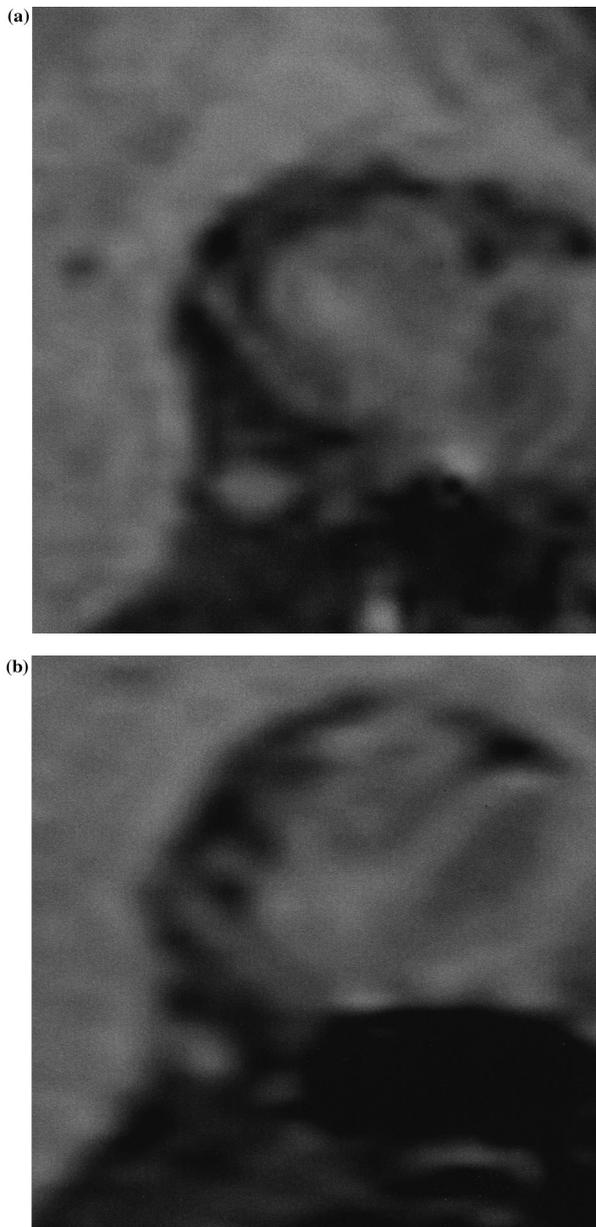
Coronal section through the body of the left hippocampus of VC (a) and the control subject (b) (T1-weighted MRI). In VC there is a general reduction of cross-sectional area.
